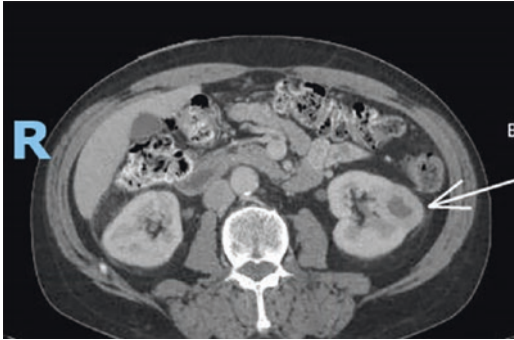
Left interpolar renal abscess in a male patient as seen on CT of the abdomen with IV contrast; this abscess resolved with antibiotic therapy, not requiring surgical drainage (Courtesy of University of Iowa, Department of Urology)
